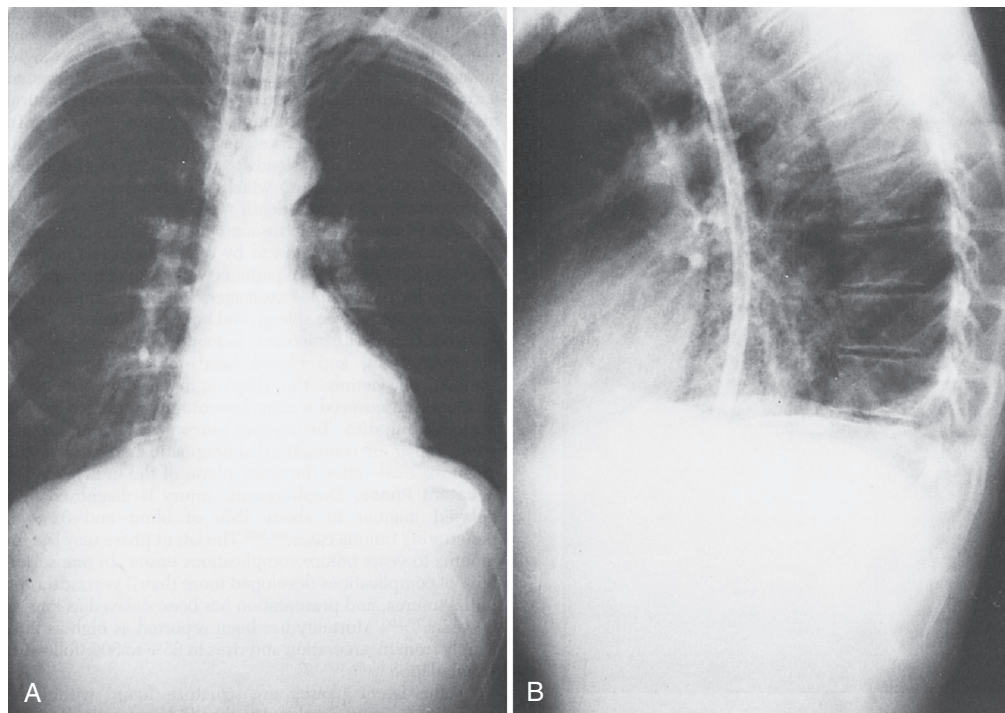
A, Chest radiograph of a 36-year-old man with acute onset of pleuritic chest pain after forceful vomiting. B, Chest radiograph shows mediastinal and subcutaneous air typical of ruptured esophagus. Mediastinum is not yet widened, and there is no soilage of the pleural cavity.
